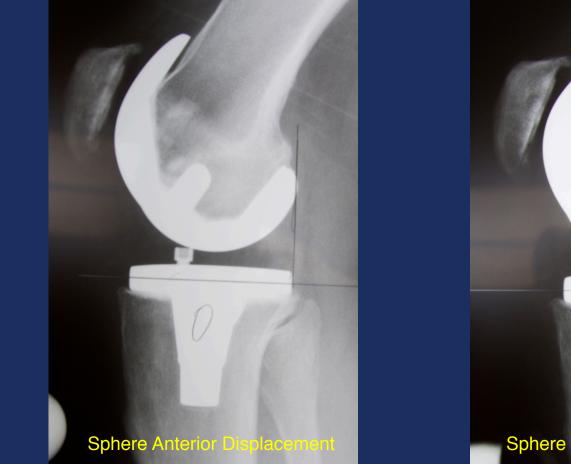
Radiographic Examples (45°) con't
